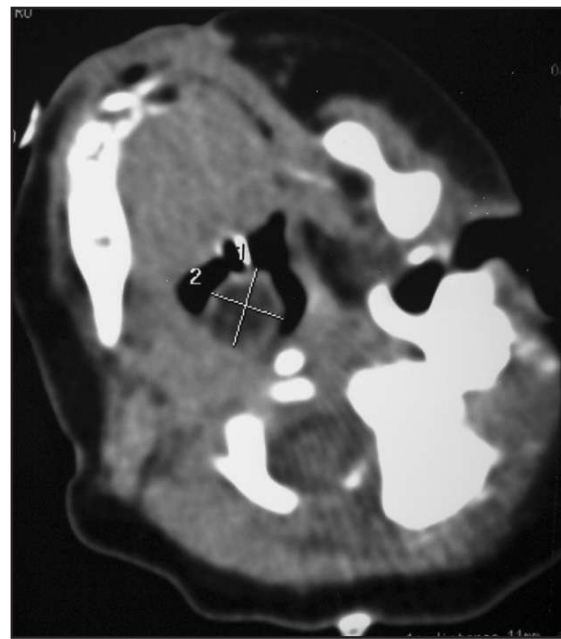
Axial CT scan showing pedunculated, postero-lateral pharyngeal mass
